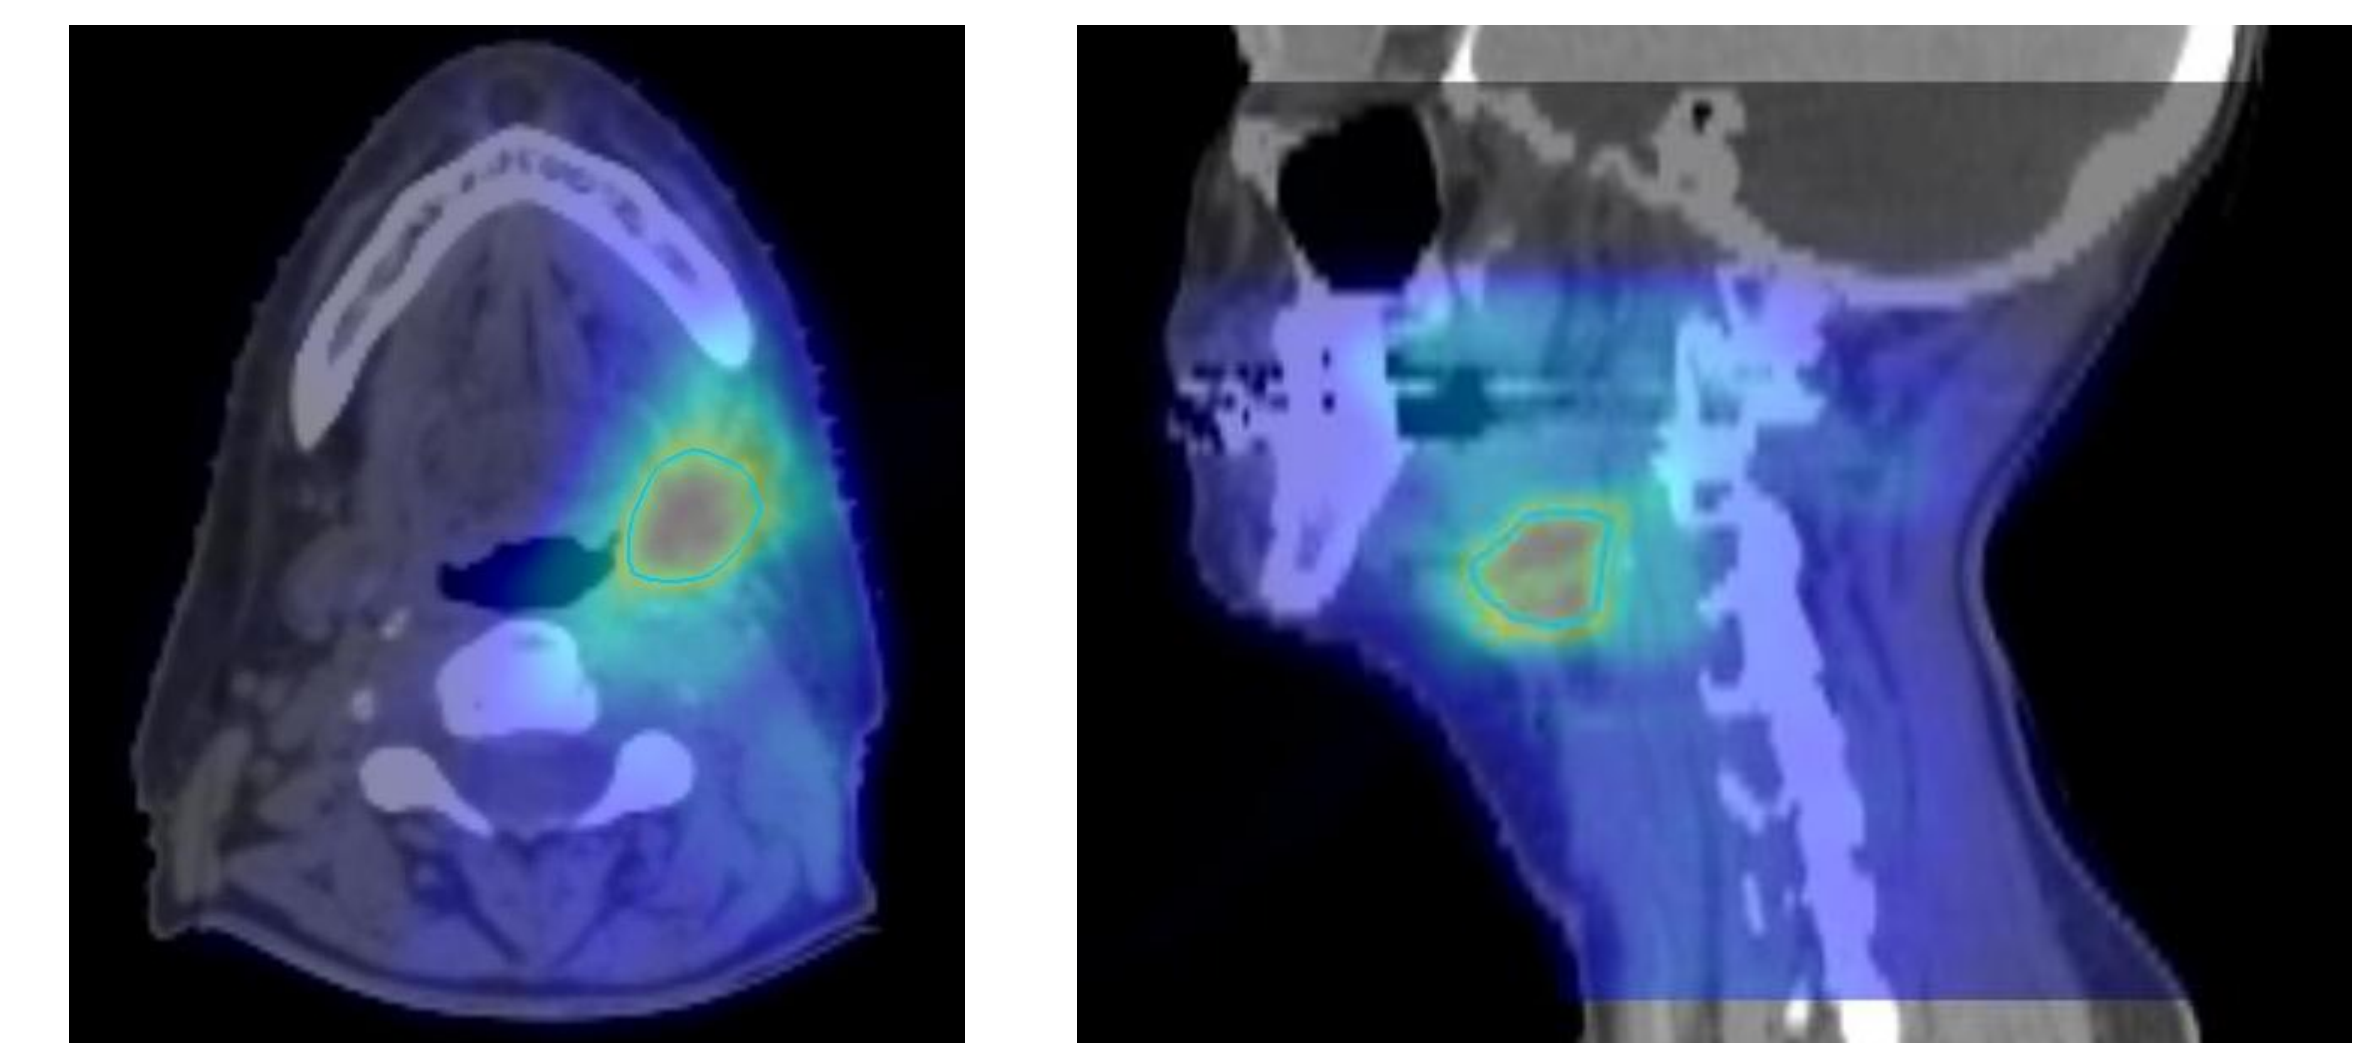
Cumulative BED distribution/planning CT overlay for the small-field head and neck case. Isodose line is 200 Gy_3 .
